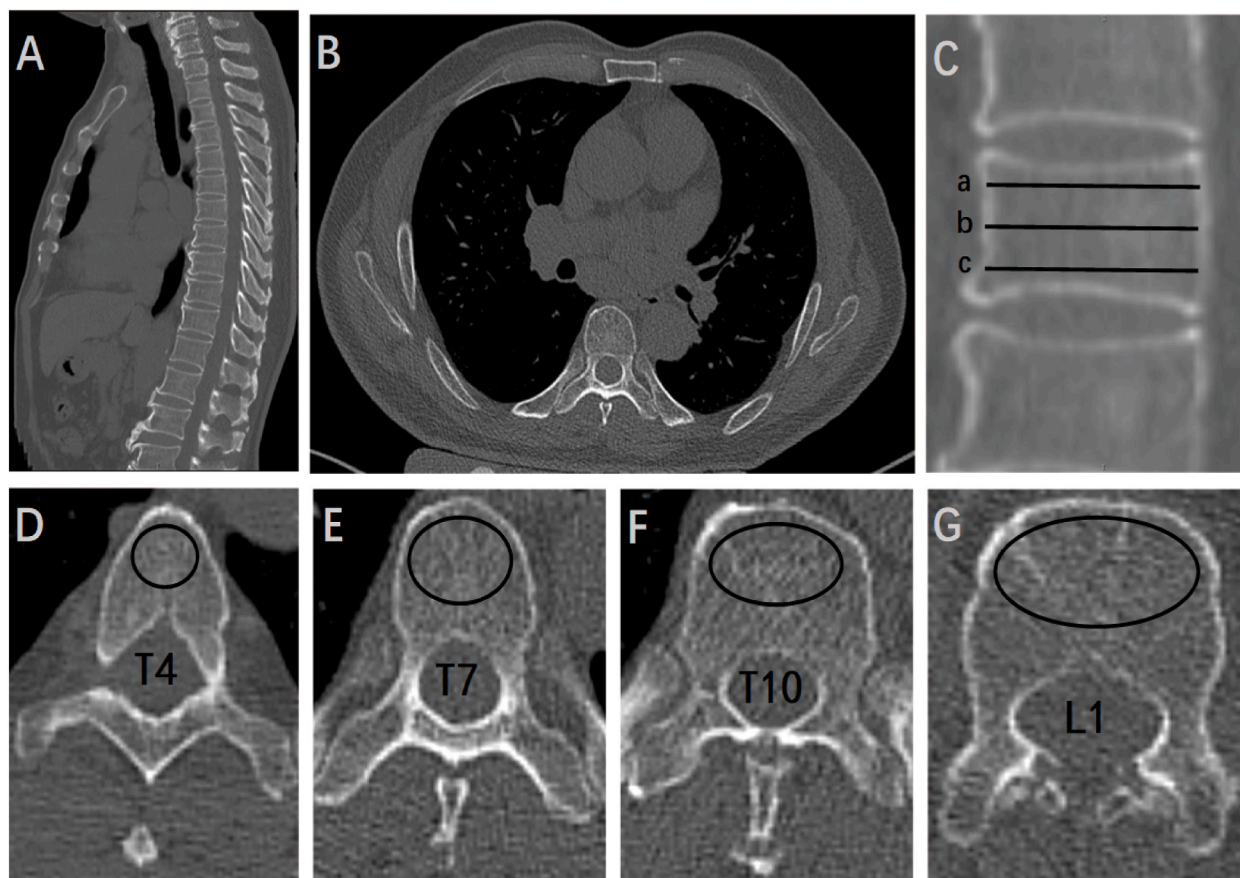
Measurement of HU value by CT. A. sagittal CT view of the chest CT; B. axial CT view of the chest CT. C locations of the assessment (a. located below the upper endplate, b. located in the middle of the vertebral body, and c. located above the lower endplate.); D-G. axial locations of the assessment on T4,7,10 and L1.
